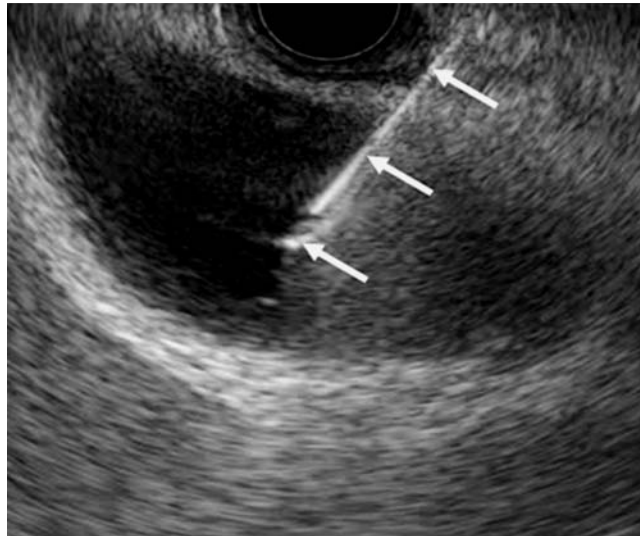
Endosonographic image of the gallbladder puncture. Arrows indicate the puncture needle.
